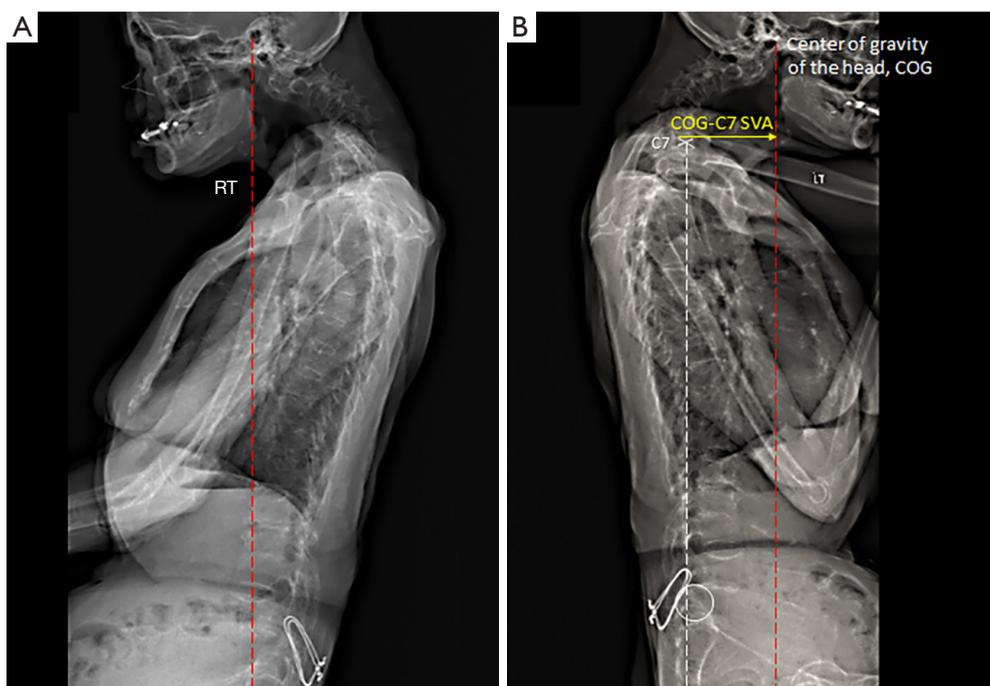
Postural assessment. (A) At initial assessment, the patient could not stand unaided. She supported herself with the right hand holding door handle and the back leaning against the cabin interior. Sagittal EOS® radiograph showed severe cervical kyphosis, degenerative spondylosis and s/p internal fixation of the sacrum. (B) At 4-month follow-up, sagittal EOS® imaging demonstrated cervical imbalance with respect to offset of the center of gravity of the head [COG–C7 sagittal vertical axis (SVA) offset, yellow arrow]. With straightening of the lumbar spine, the C7 plumb line (dashed white line) was tangential to the posterior-superior corner of the upper sacral endplate (white circle), suggestive of a compensated global sagittal balance. In the sagittal plane, the gravity line (dashed red line) passes slightly posterior to the hip joint.
